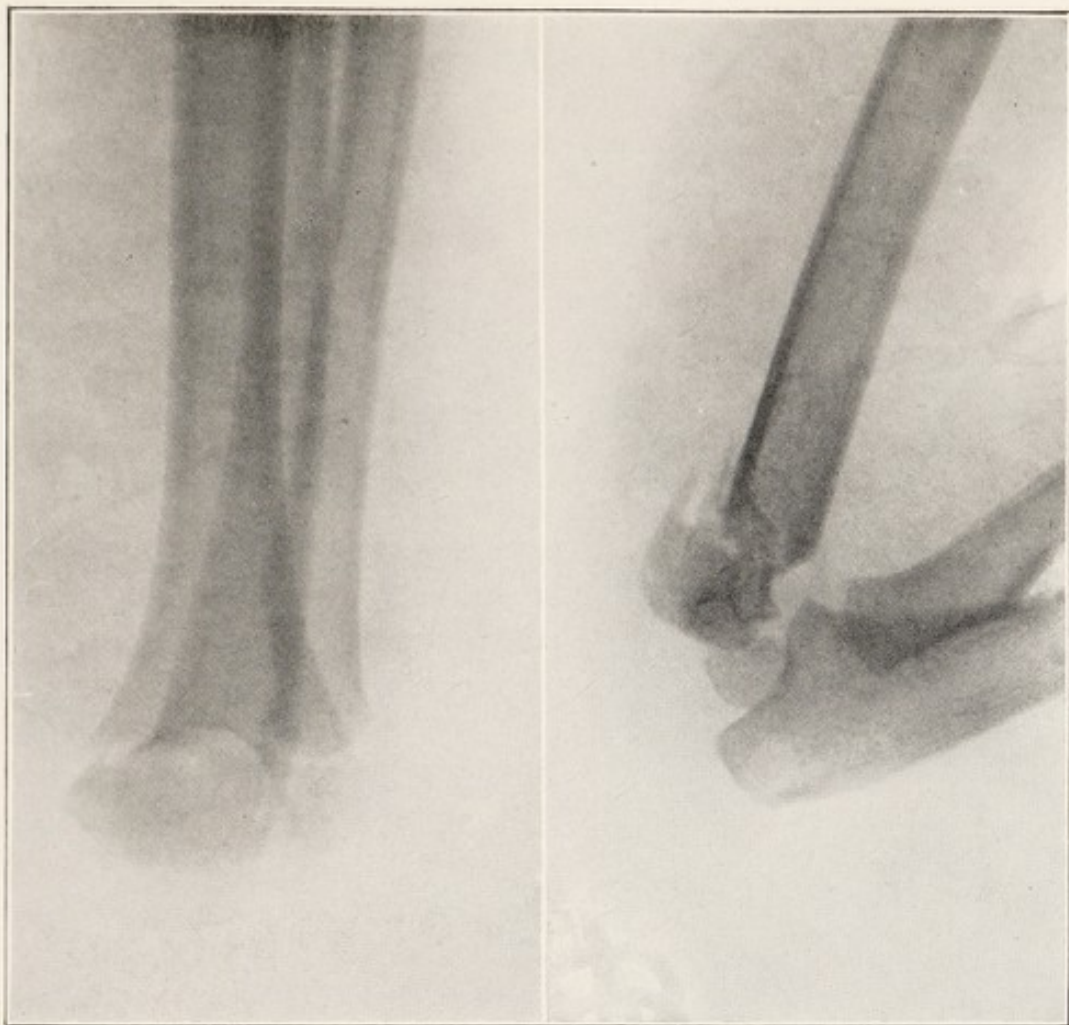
X-RAY SHOWING SUPRA-CONDYLAR FRACTURE OF HUMERUS, ANTEROPOSTERIOR VIEW.
